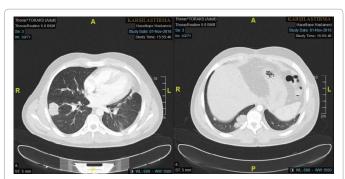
The patient thorax CT that shows metastatic pulmonary lesions (red arrows) pre-op.
